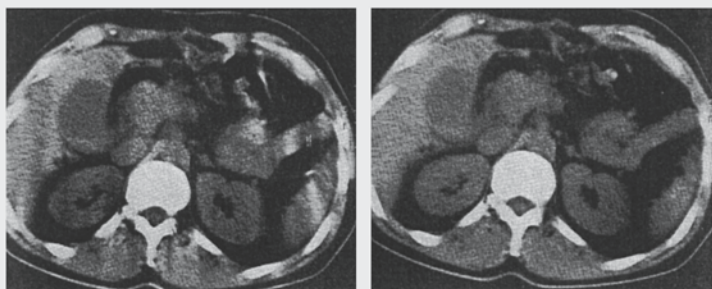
Image quality in spiral volumetric CT scans. (a) Direct reconstruction from the spiral data results in motionlike artifacts. (b) Reconstructions from synthesized planar data are free from such artifacts.
